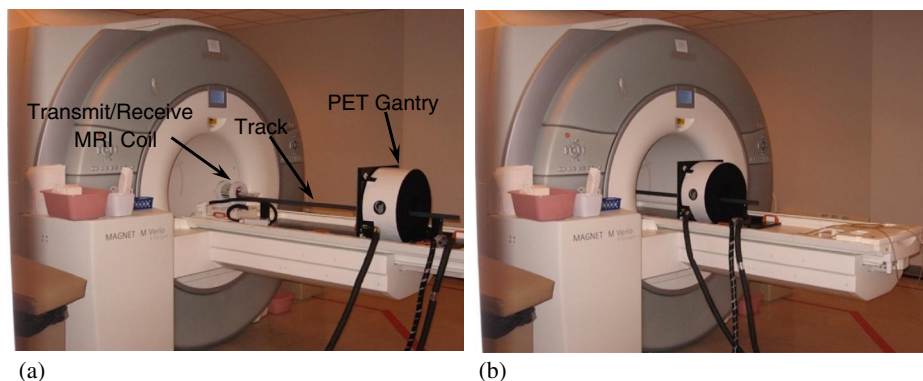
Pictures of the WVU-PET/MRI insert at its (a) extracted and (b) inserted positions. Note the cooling tubes and signal cable bundle leading to the PET gantry.
